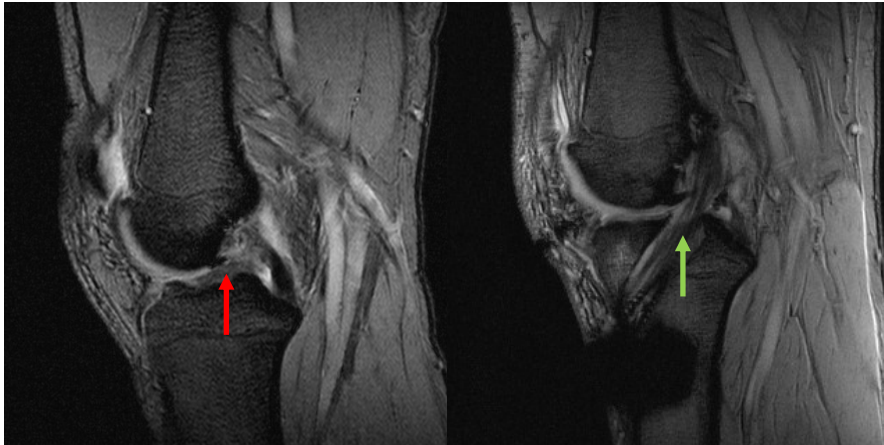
Magnetic Resonance Imaging of a torn ACL (red arrow) and reconstructed ACL (green arrow)
